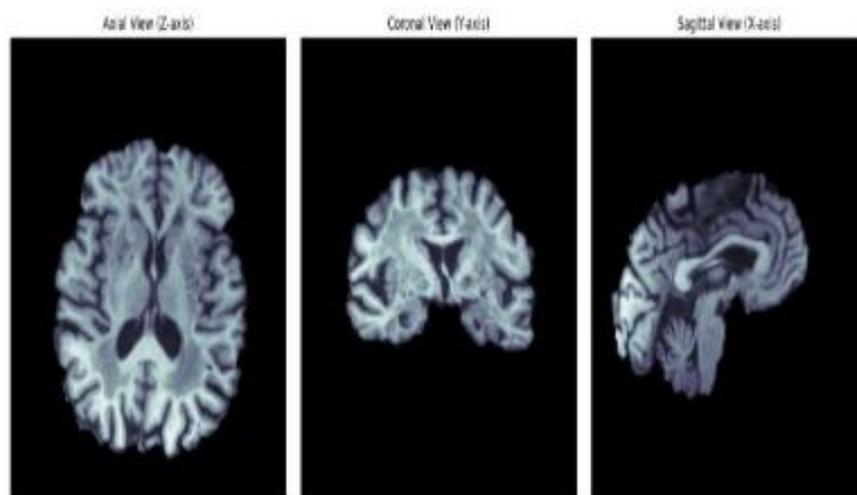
Example of a brain MRI image after preprocessing steps
